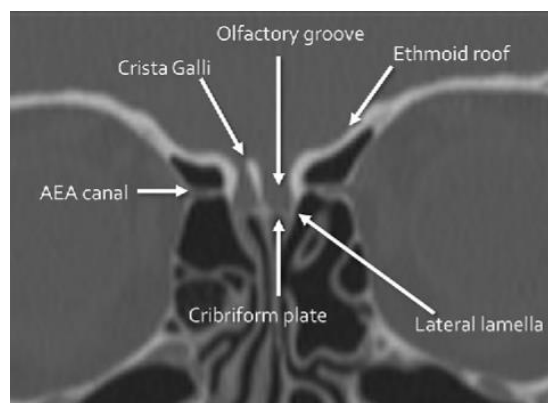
CT showing lateral lamella and cribriform plate
